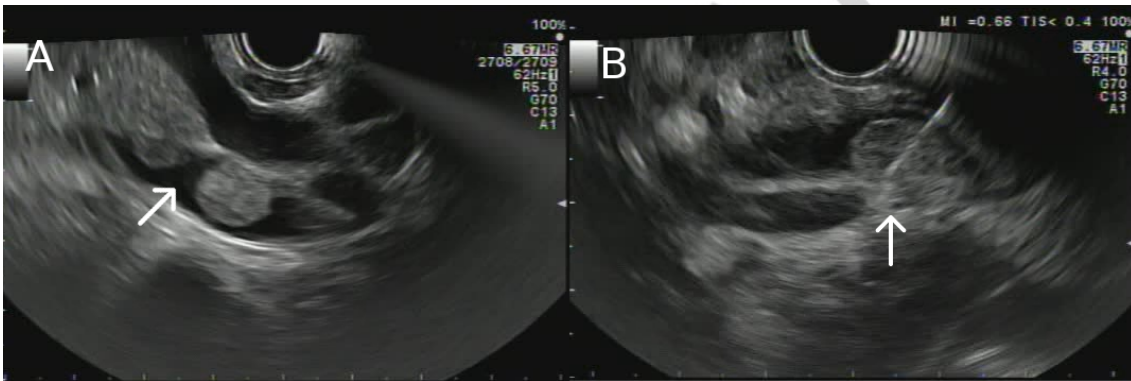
Endoscopic ultrasound showing two polypoid intraductal masses (7 and 20 mm in diameter, respectively) located in a dilated common bile duct (A). Endoscopic ultrasound-guided fine needle aspiration of the largest lesion was performed (B).
